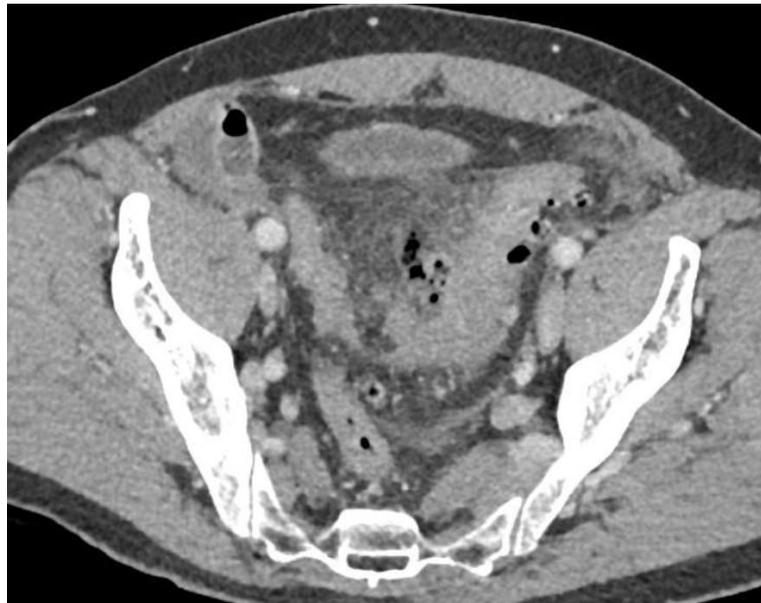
Axial CT showing colonic diverticulitis with perforation (31)
